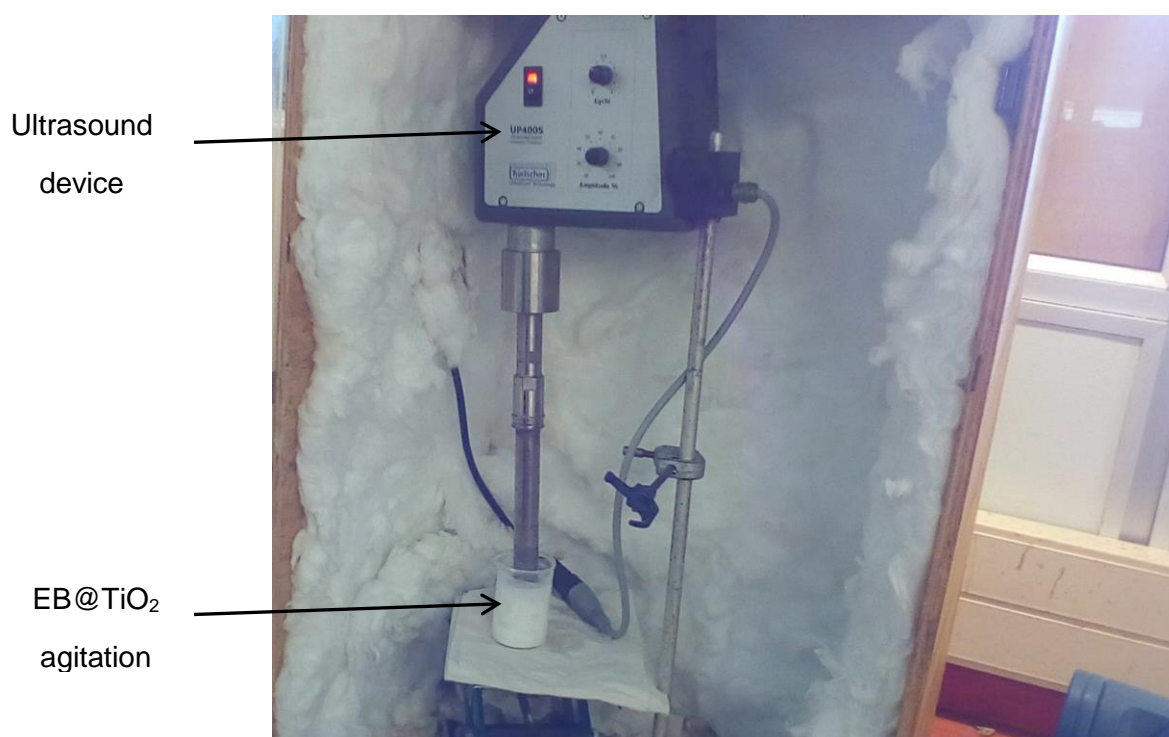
4: Agitation of EB@TiO₂ using ultrasound technology
